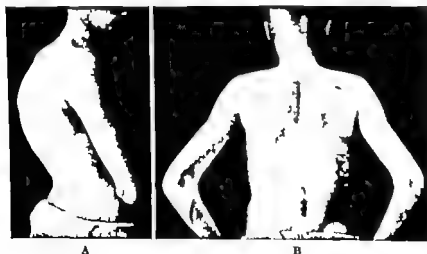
The history and roentgen-ray findings on this patient are given on page 804
